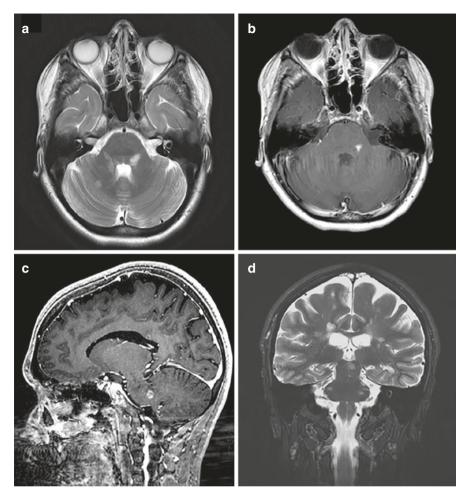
Left brainstem lesion in a patient with multiple sclerosis. (a) Axial T2-weighted image. (b, c) Same lesion showing abnormal enhancement on post-contrast T1-weighted images, indicating an active lesion. (d) Multiple associated lesions with typical distribution in the subcortical, periventricular and ponto-medullary white matter on coronal T2-weighted images
